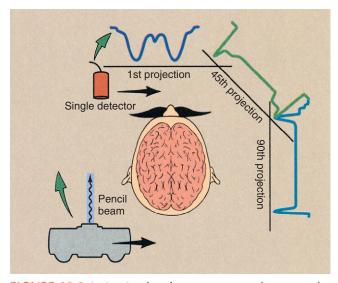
In its simplest form, a computed tomography (CT) imaging system consists of a finely collimated x-ray beam and a single detector, both of which move synchronously in a translate and rotate fashion. Each sweep of the source detector assembly results in a projection, which represents the attenuation pattern of the patient profile.
